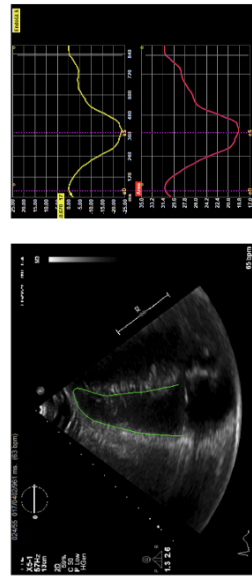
Example of Speckle Tracking Echocardiography assessment
